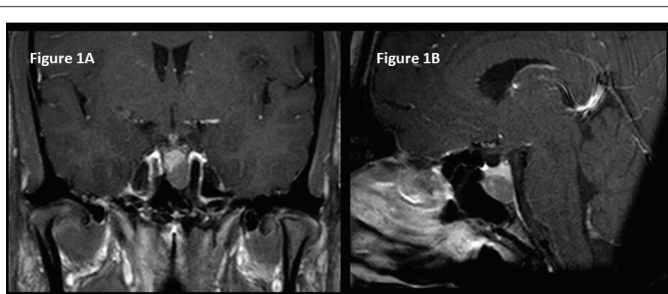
A and B) Pituitary MRI revealed a 1.4 cm × 1.2 cm × 0.8 cm ovoid hypoenhancing sellar mass.
